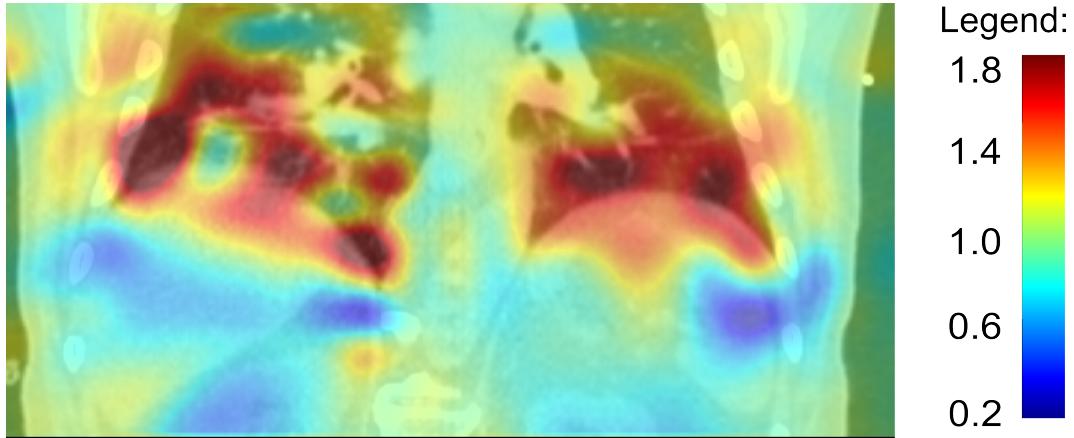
Image of Jacobian overlayed on a CT scan. The average value of the displayed Jacobian is 0.98 with 0.09 standard deviation.
